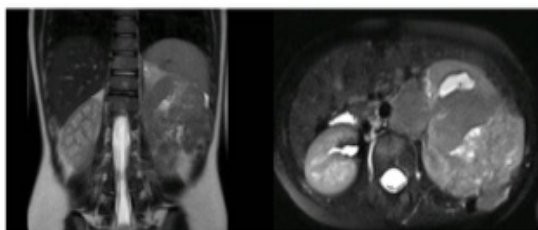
MRI image of the mass.
